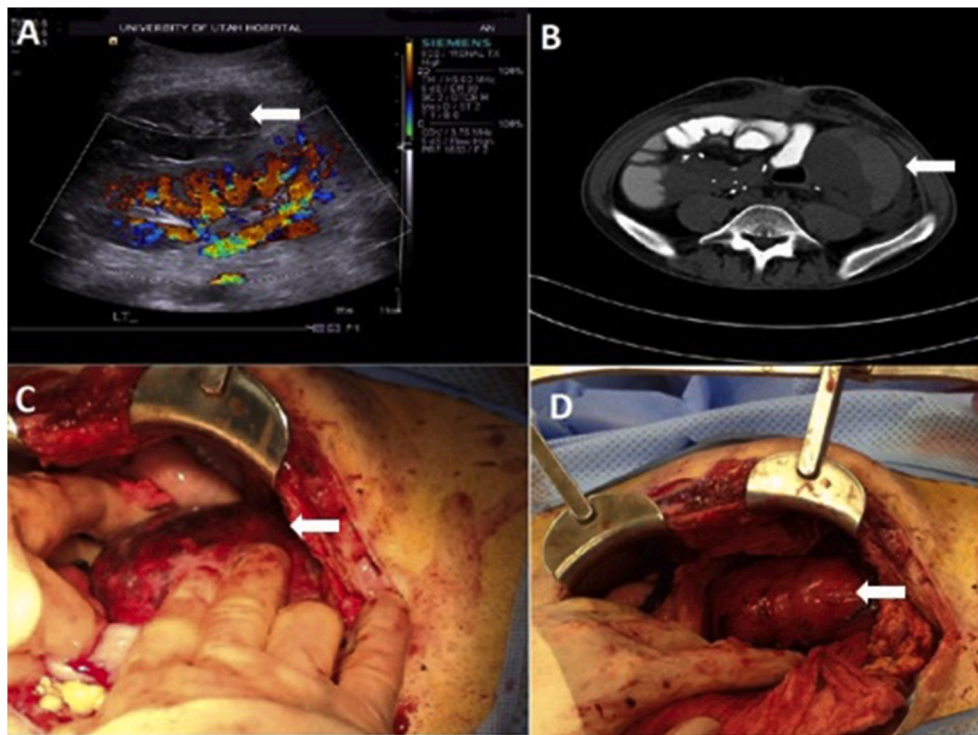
A-US, B- CT, C-Before decapsulization, D- After decapsulization (white arrows indicate to hematoma).
